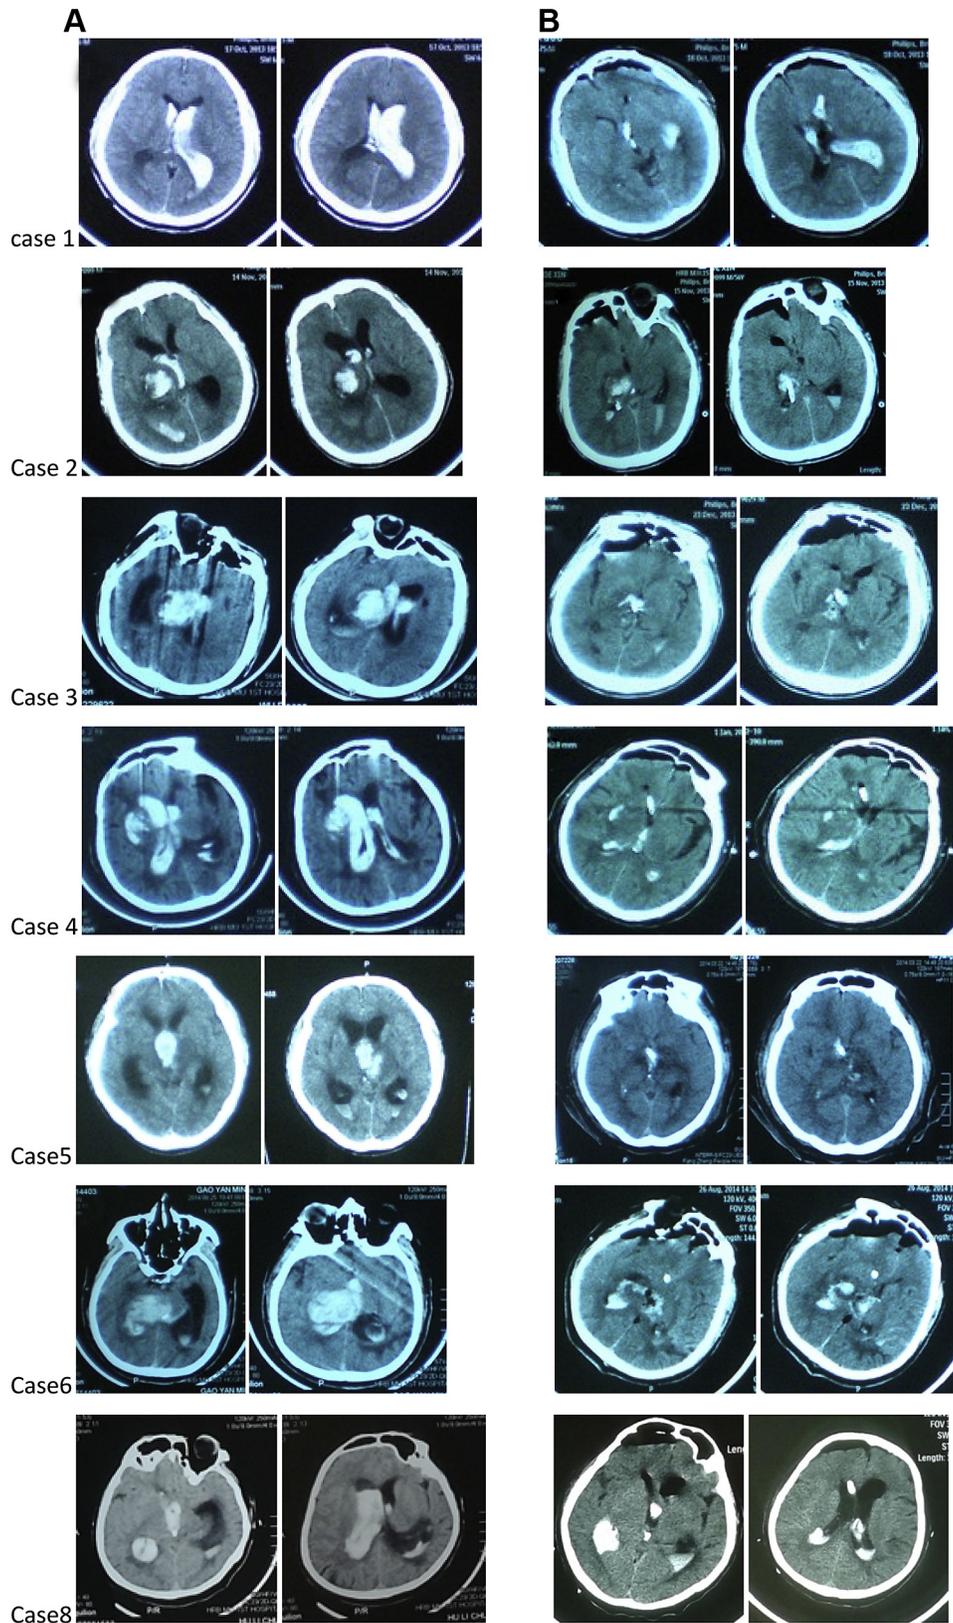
Preoperative (A) and postoperative (B) computed tomography scans of each patient in this study except for case 7.
